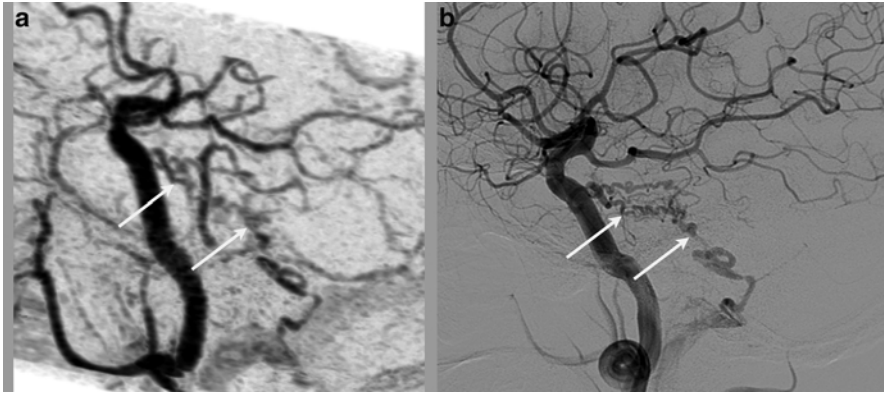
A 47 y/o male presented with right-sided pulsatile tinnitus. 4D-CTA (a) of the posterior circulation demonstrates a tentorial dural AV fistula (*white arrows*), confirmed at DSA (b). Courtesy of F.J.A. Meijer, Radboud UMC, Nijmegen, The Netherlands
